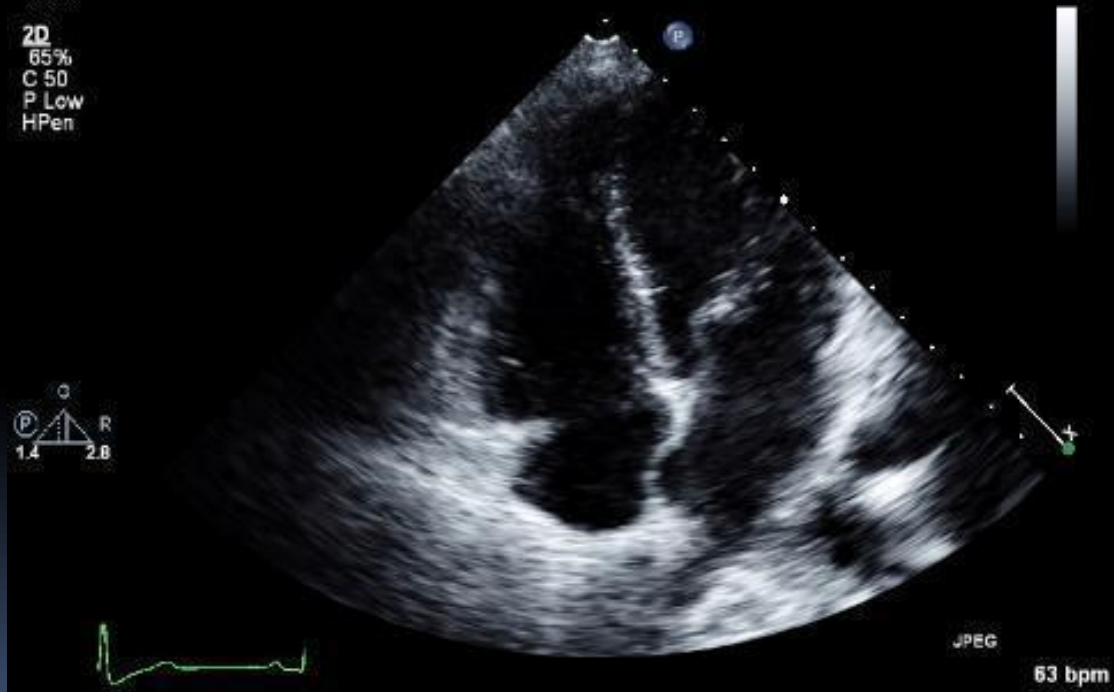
4: Apical 4-chamber view
